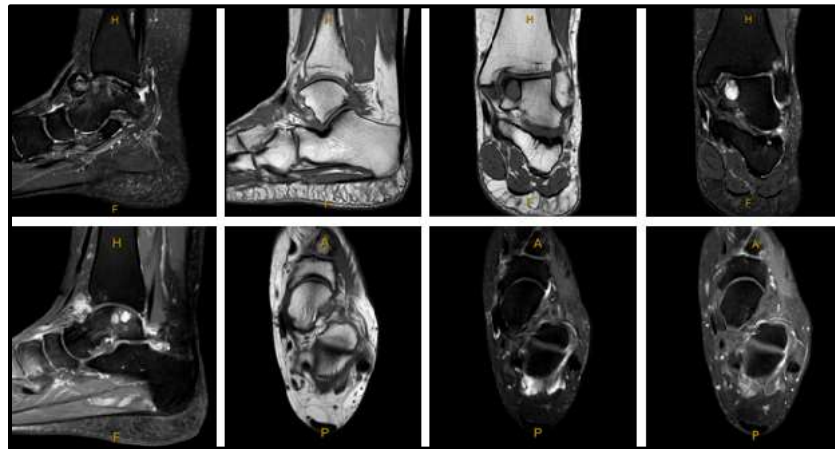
Initial MRI scans of patient's left ankle.
